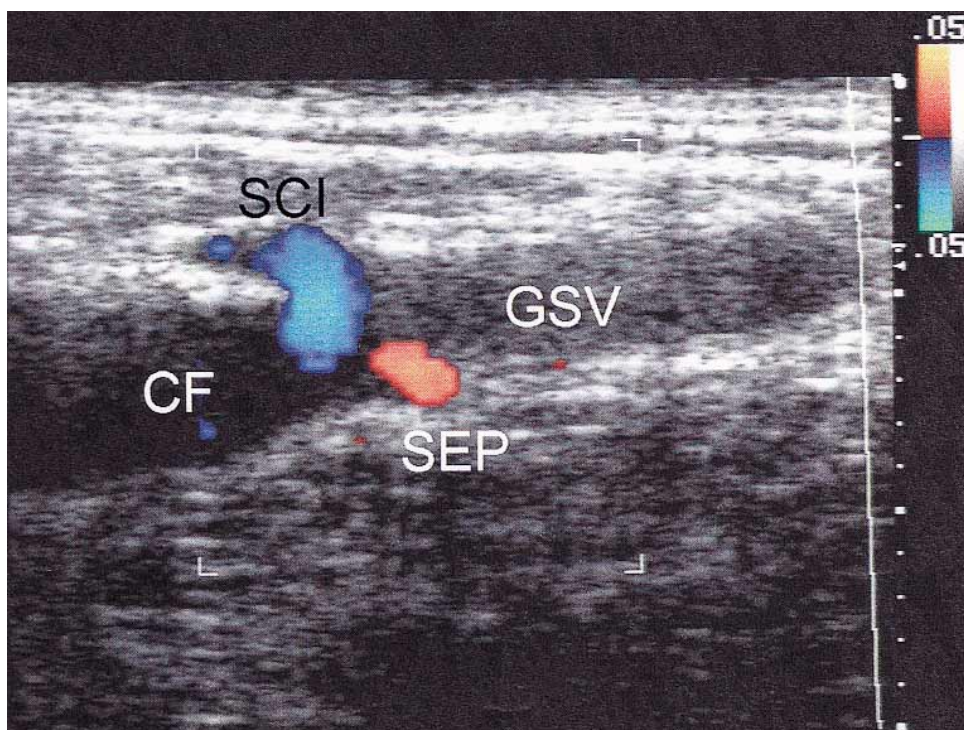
Color flow duplex scan showing patency of the superficial, circumflex, iliac (*SCI*, *blue flow*) and the superficial, external, pudendal (*SEP*, *orange flow*) veins, which were both initially occluded, with noncompressible obliteration of the GSV at 6 months. The common femoral vein (*CF*) flow axis is perpendicular to the color Doppler scan insonation plane.
